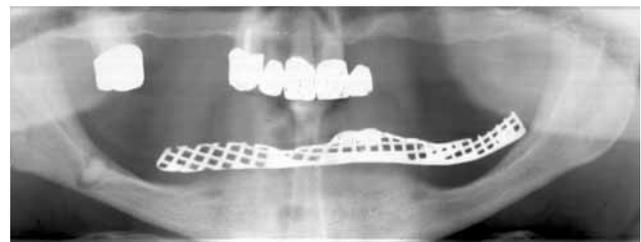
panoramic radiograph of the patient revealing the root remnant that caused the patient's paresthesia
